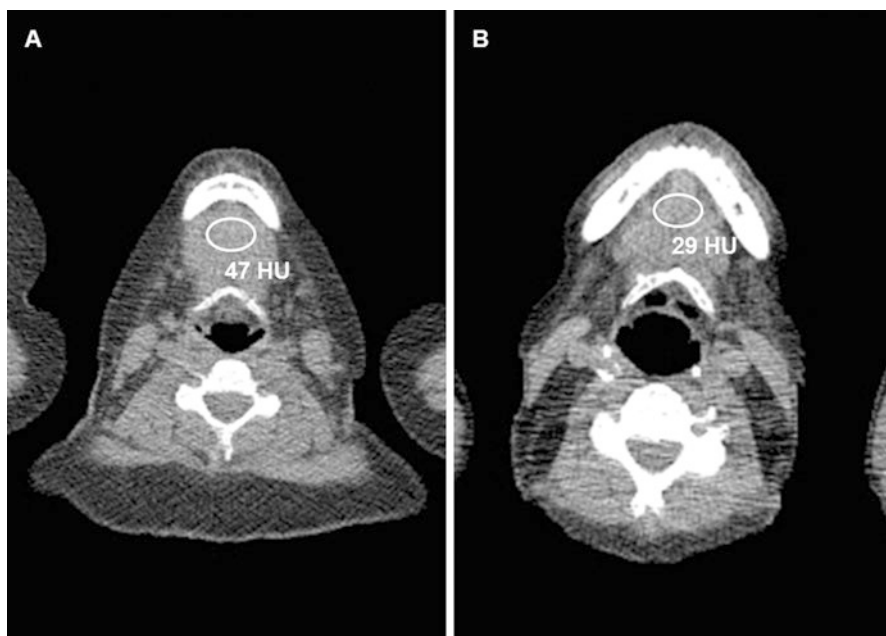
Non-contrast CT of the neck for assessment of tongue adipose tissue in a 63-year-old woman (BMI, 34 kg/m²) (a) and 63-year-old man with similar BMI (BMI, 35 kg/m²) (b). The man had lower CT attenuation of the tongue compared to the woman, consistent with fatty infiltration. Images are presented by using the same window and level
